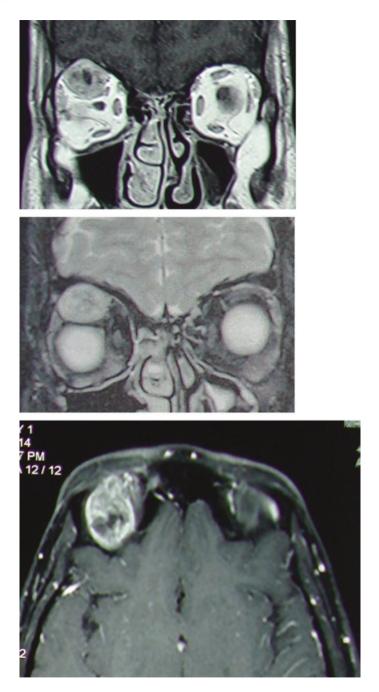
MRI, reveals the tumor that is hypo-intense in T1W image (a) and hyper-intense in T2W image (b). After contrast administration enhancement starts from peripheral area (c)
